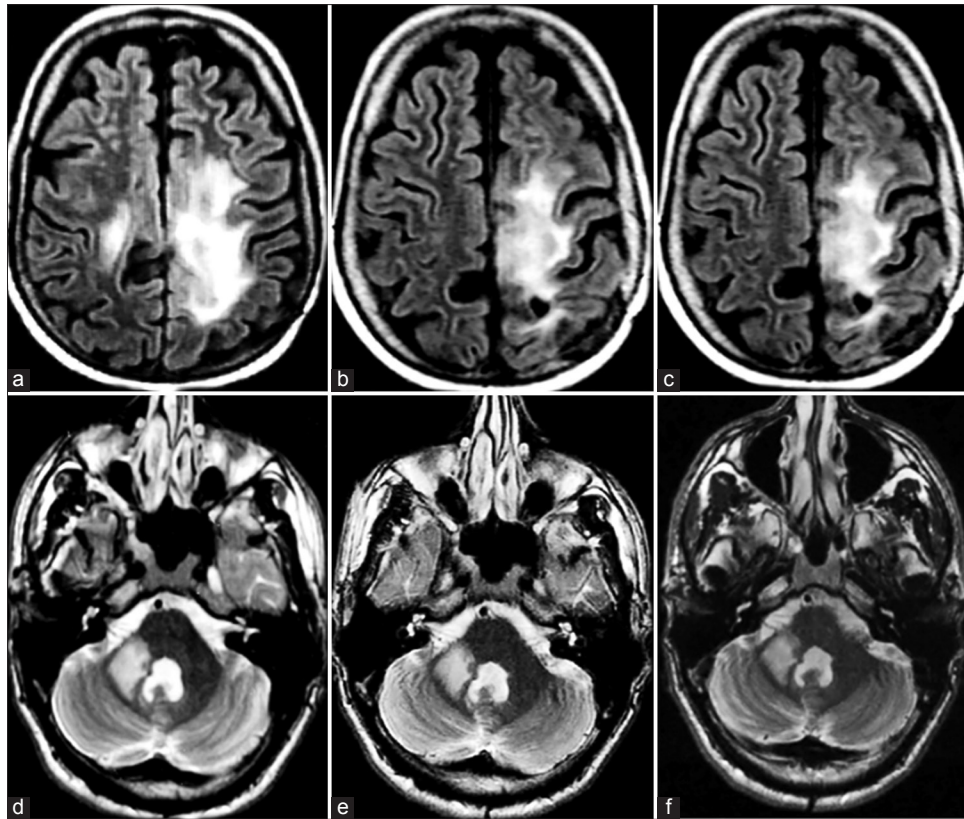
Representative MRIs of LGG patients under intranasal POH treatment. One patient presented reduction of tumor size after 3 years (b) and 6 years (c) of POH treatment in comparison with first image obtained before treatment (a) Conversely, compared with initial MRI (d) a second patient maintained stable disease after 3 years (e) and 5 years (f) of treatment with POH
